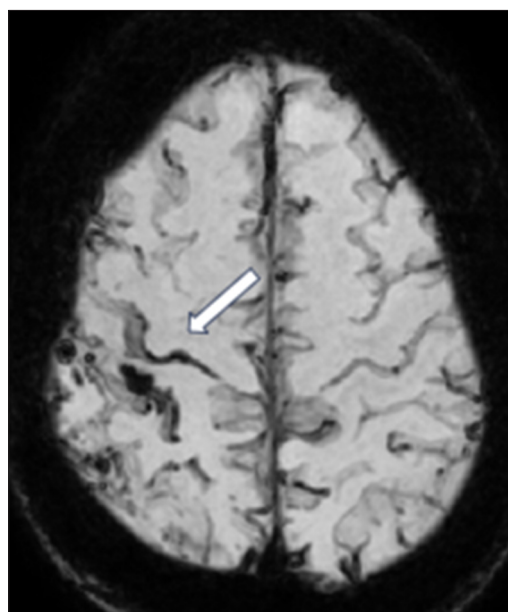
Susceptibility-weighted imaging magnetic resonance imaging from March 2025 reveals superficial cortical siderosis (white arrow).
